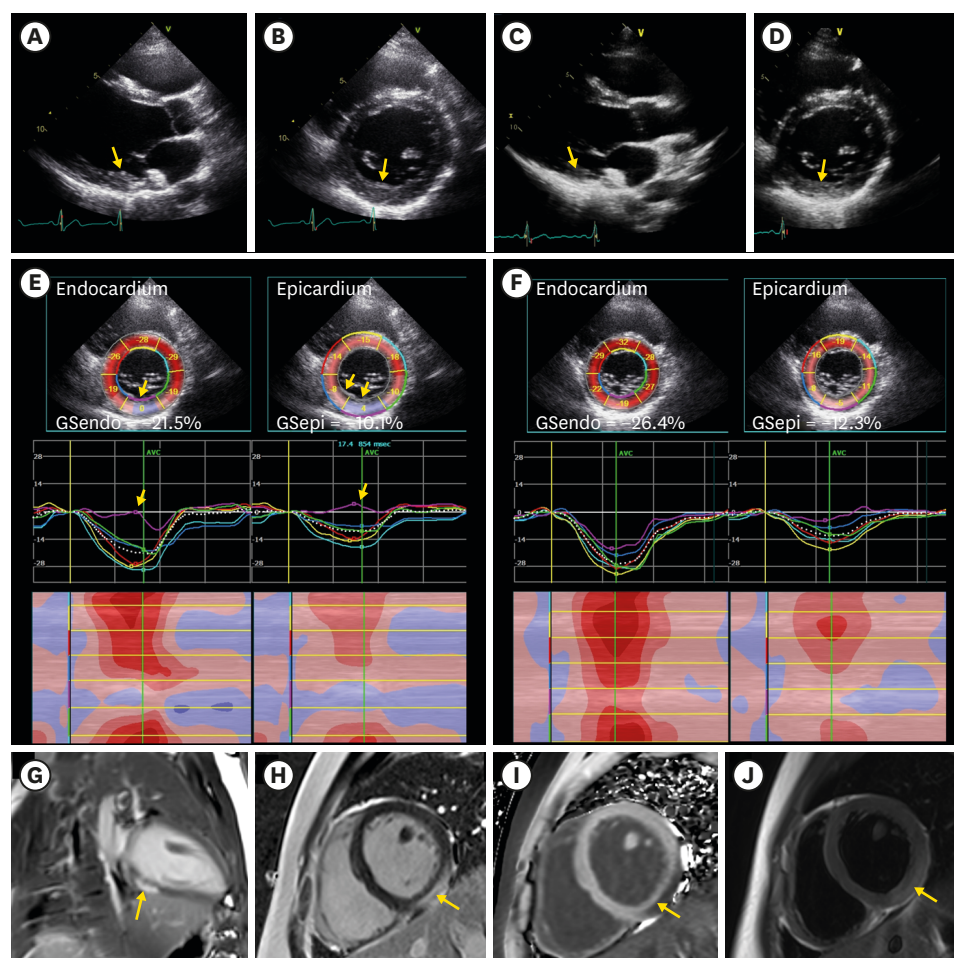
Echocardiographic and magnetic resonance images. (A, B) Mild thickening of posterolateral segment at the basal left ventricle on two-dimensional echocardiogram (arrow). (C, D) Improved wall thickening of the posterolateral segment at the basal left ventricle on two-dimensional echocardiogram (arrow). (E) Impaired circumferential strain at posterolateral wall on speckle tracking echocardiogram (arrow). (F) Abnormal circumferential strain values were improved at 2 weeks of follow-up speckle tracking echocardiogram. (G, H) Subepicardial delayed enhancement in basal inferior and posterolateral walls on cardiac magnetic resonance (arrow). (I) Increased native T1 value on cardiac magnetic resonance (arrow). (J) Increased T2 value on cardiac magnetic resonance (arrow).
